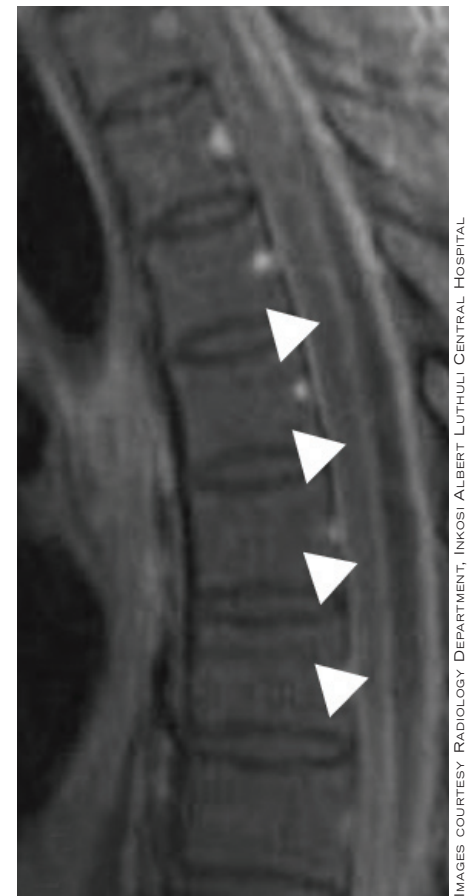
Sagittal MRI scan of the spinal cord with an epidural tuberculous abscess (arrows). Note there is no bony disease.
